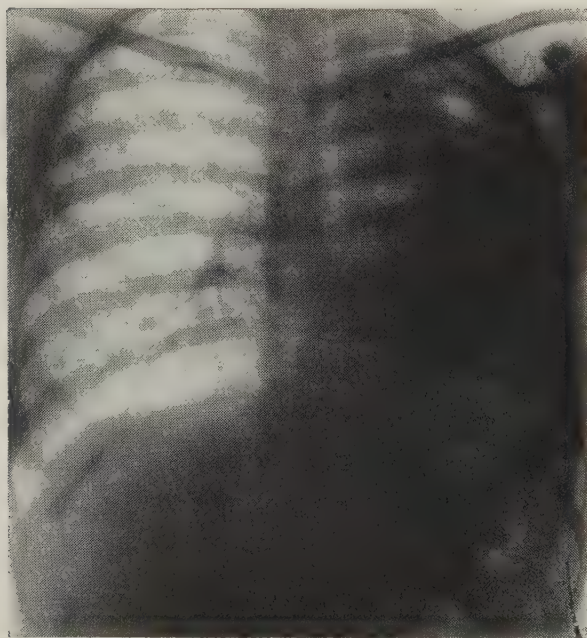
Patient J. deG. Roentgenographic examination shows destruction of the left lung.
